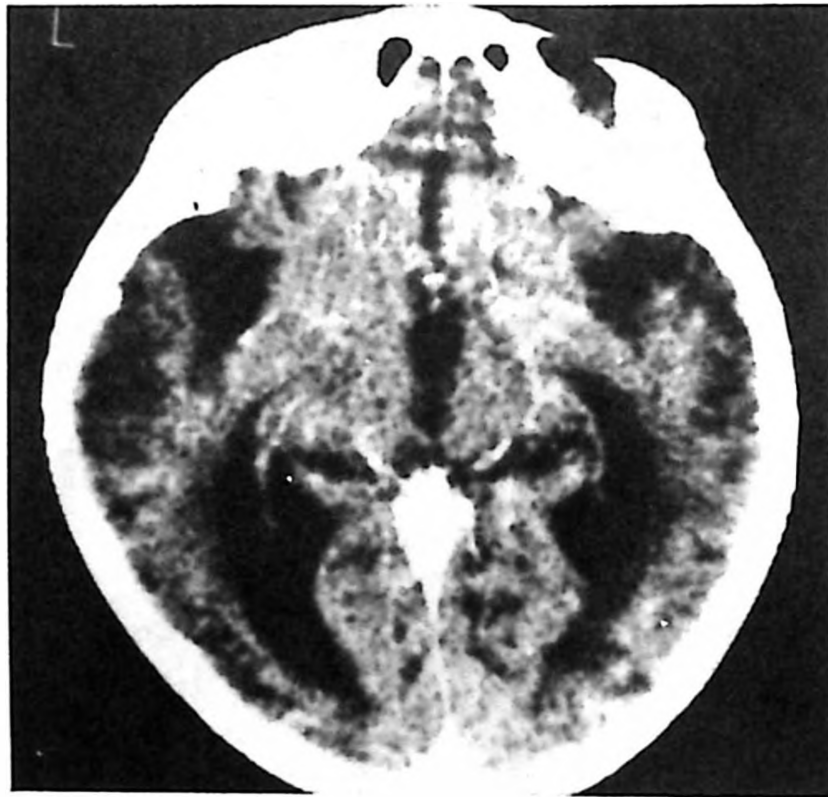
Case 5: CT showed linear vessels in basal ganglia representing abnormal net-like vessels. Note dilated temporal horns and subarachnoid space secondary to cerebral atrophy.
